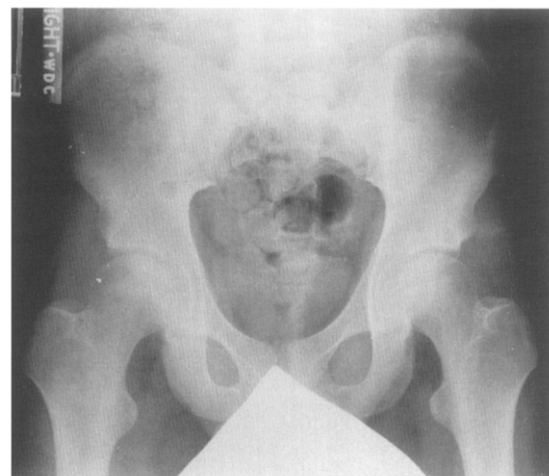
Follow-up hip radiograph after 1 year of thyroid replacement showing no bone or joint abnormality.
